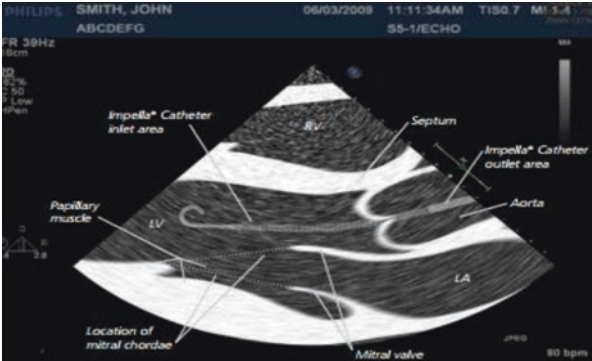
Correct Impella catheter position on transesophageal echocardiogram long-axis view
